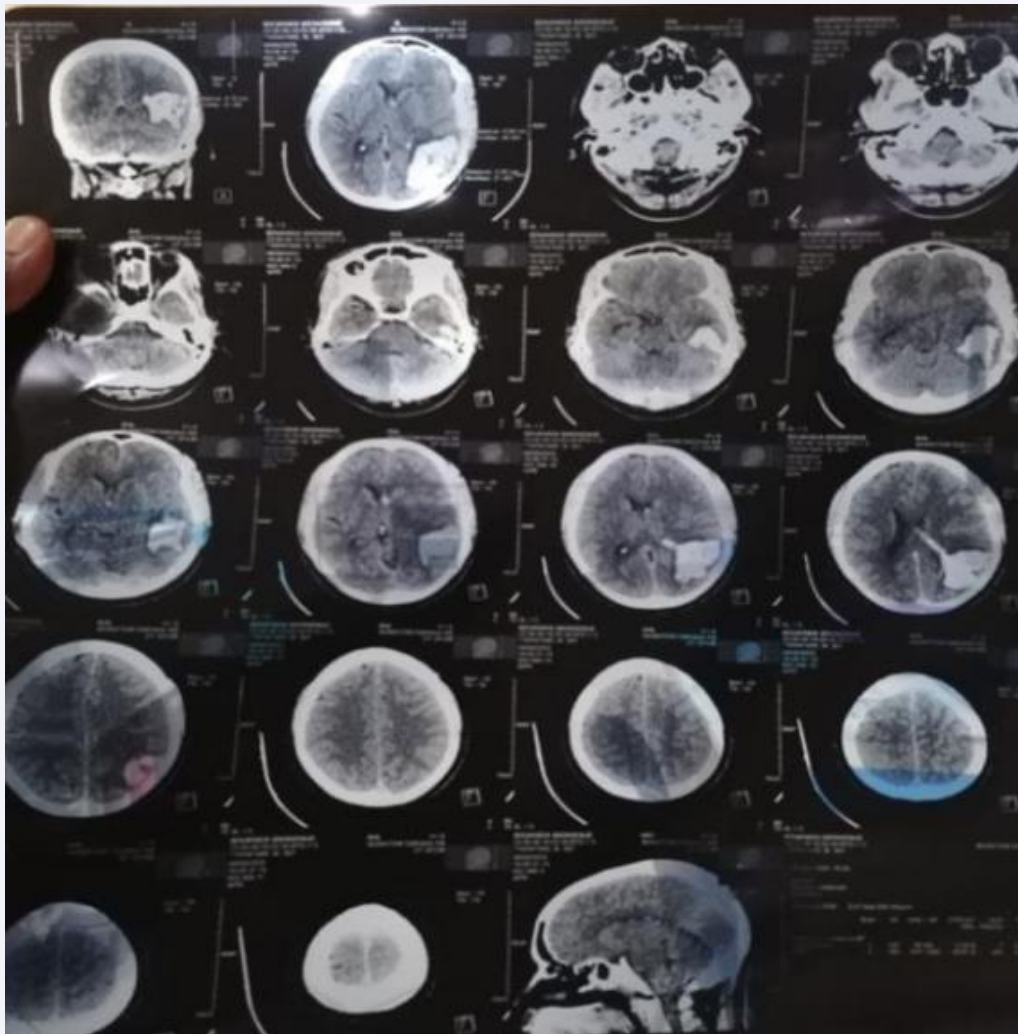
CT scan at AVCH patient 2.
